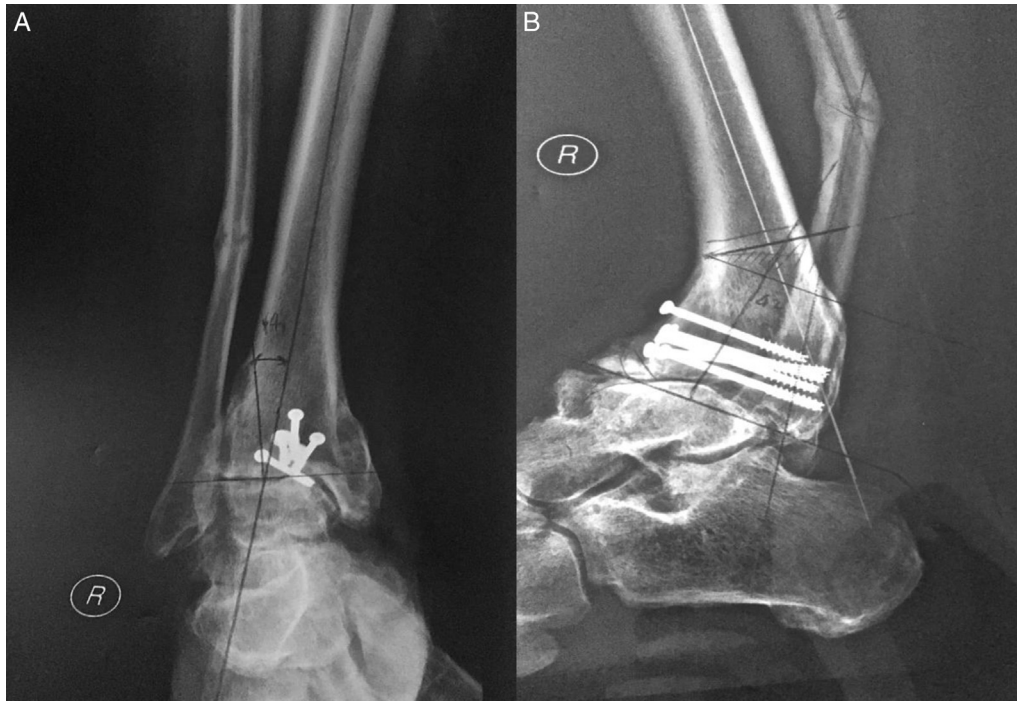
Preoperative clinical radiographs. (A) Anteroposterior radiograph of tibial malunion. Note screws from previously performed operation, which resulted in malunion. (B) Lateral radiographs demonstrating tibial malunion and recurvatum of right tibia and fibula. The screws seen represent those from the initial operation to correct the original fracture, which resulted in malunion. Also note severe post-traumatic arthritis of the tibio-talar joint secondary to tibial angulation. Posterior wedge osteotomy was performed to correct the deformity. Dark lines represent the axes of the proximal and distal segments of tibia and were used to determine the size of the osteotomy performed.
